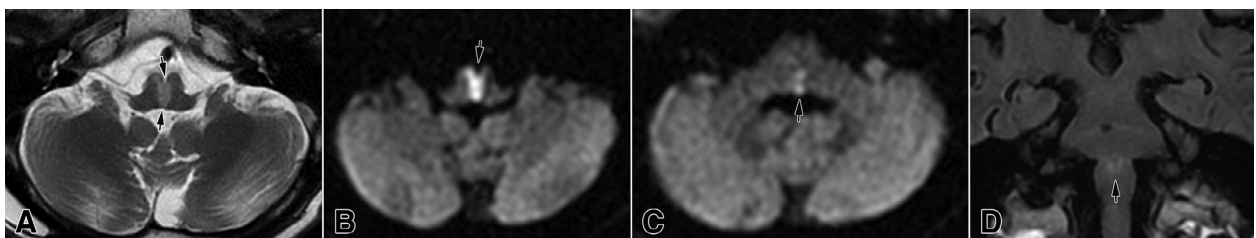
The "heart appearance sign" of a bilateral middle infarction (arrows) in the axial T2-weighted (A) and DWI (B and C) images, as well as in the coronal FLAIR section (D). Note the extension of the ischemia into the medial paraventricular region of the pons (arrow in C).
